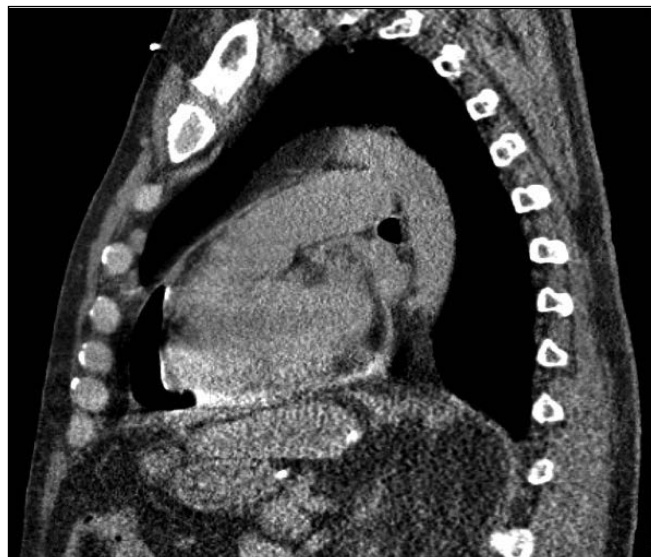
Sagittal CT scan of the chest with abdominal window showing pneumopericardium.
